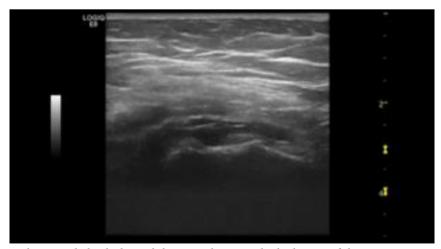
The immediate ultrasound check showed the spreading, inside the bursa, of the oxygen-ozone mixture and the immediate volumetric reduction of the bursal fluid component.
